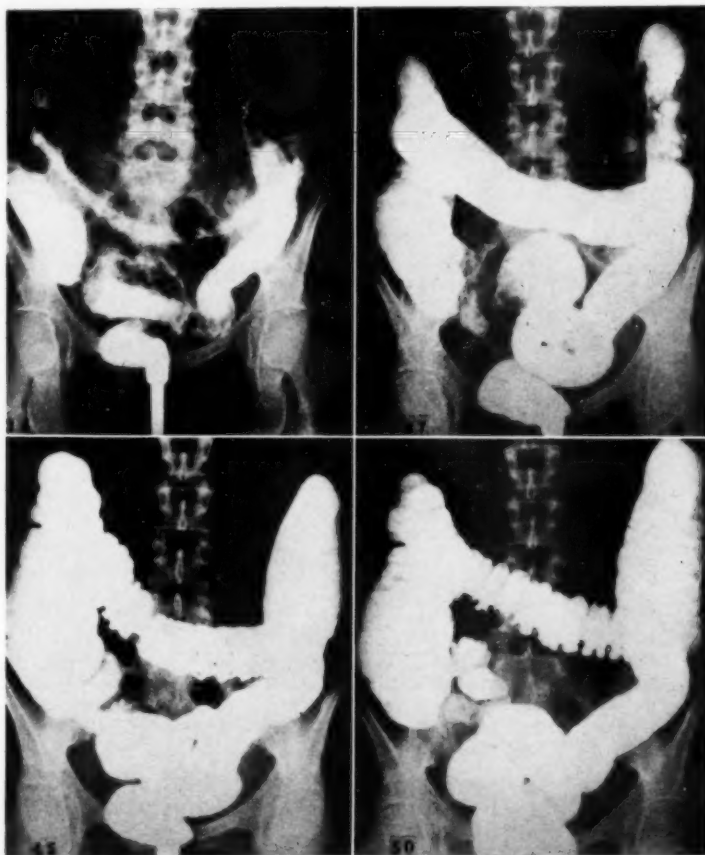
L. G. H. Reversal of roentgen changes of ulcerative colitis. Severe disease in 1934; normal colon in 1950.
